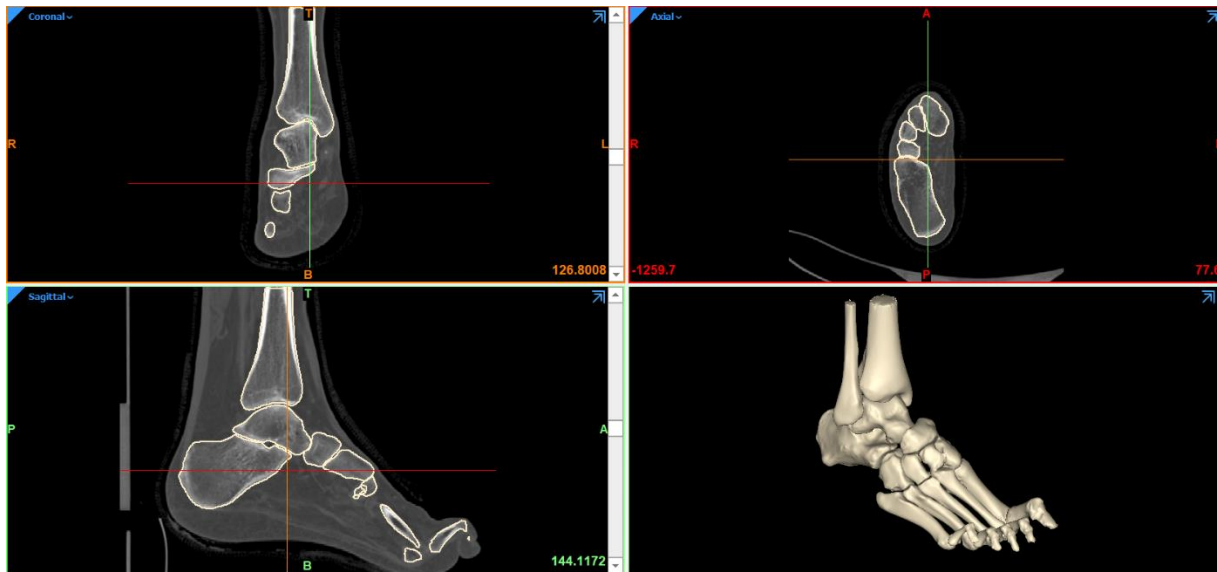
CT data of the preoperative foot of case C, neutrally aligned using a total contact cast. Coronal (top left), Axial (top right) and Sagittal (bottom left) multiplanar reconstructed (MPR) views of CT data. The 3D model constructed from CT data is shown in the bottom right corner.
